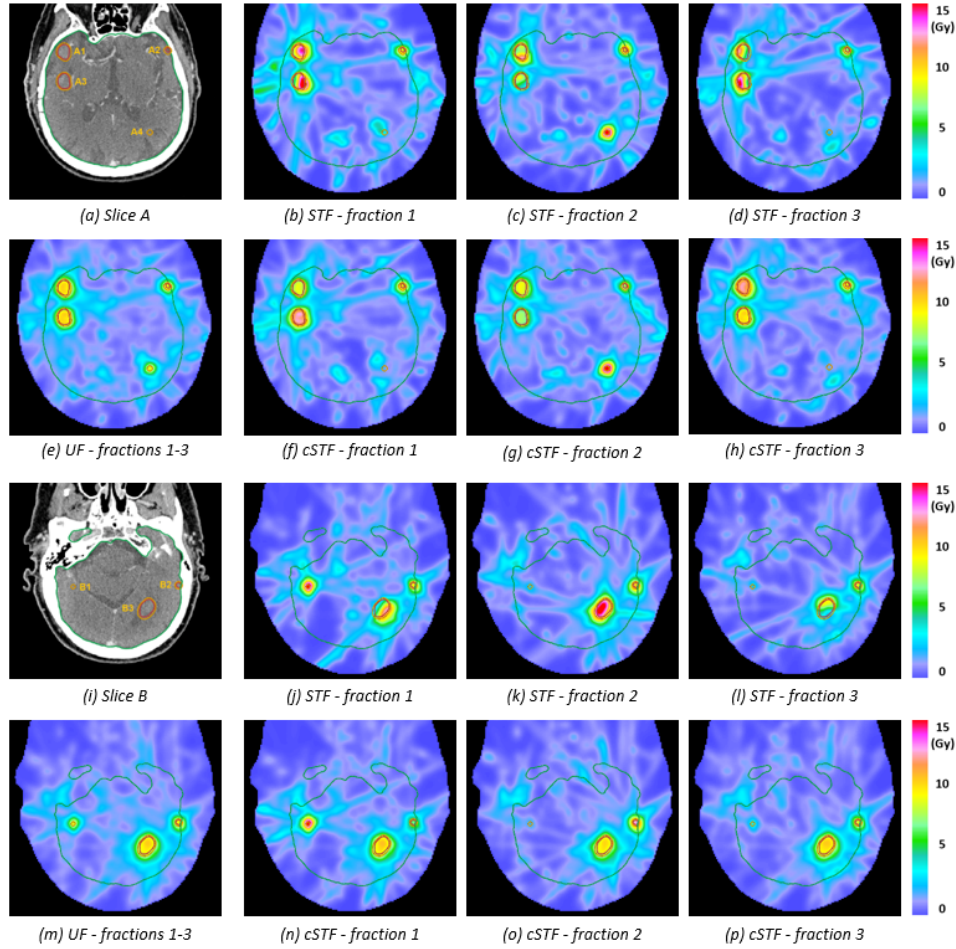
Dose distributions for two CT slices of patient 1 achieved with the different fractionation schemes. In slice A (a), four metastases are visible with PTV volumes of 3.2 cc (A1), 0.3 cc (A2), 2.3 cc (A3) and 0.1 cc (A4). In slice B (i), three metastases are visible with PTV volumes of 0.1 cc (B1), 0.4 cc (B2) and 9.9 cc (B3). For each lesion, contours for the GTV (red) and PTV (orange) are shown. Also shown is the contour of the brain (green).
